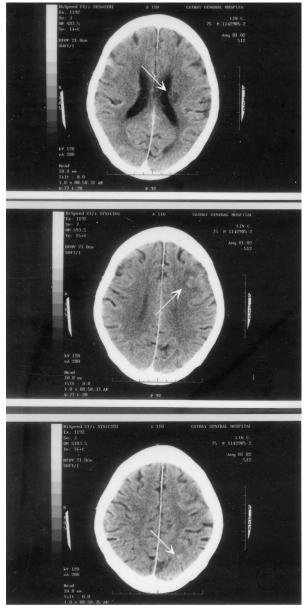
Brain CT with contrast medium shows three focal brain softenings over the left frontal area with rim hyperdensity (upper: white arrow), left deep subcortical with hypodense shadow (middle: white arrow), and left posterior parietal area with contrast enhancement (lower: white arrow).
